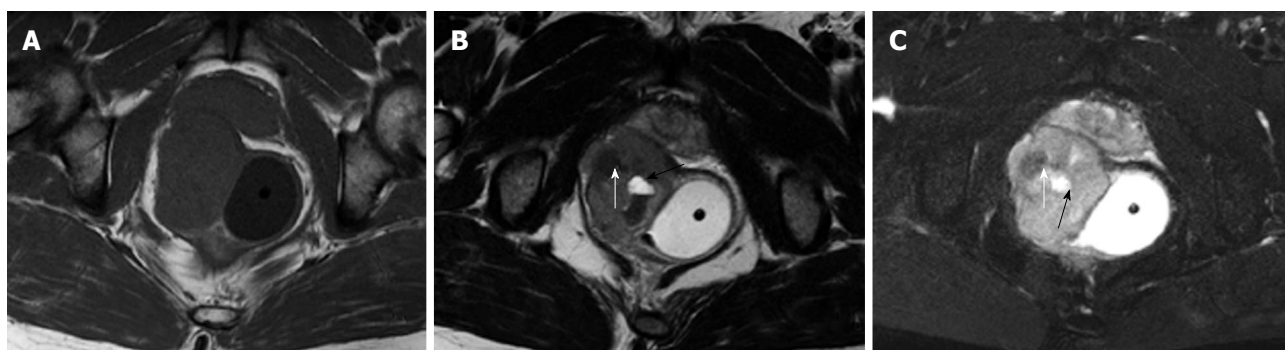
Gastrointestinal stromal tumors of rectum in a 44-year-old man. A well-circumscribed, smooth, intramural mass with exophytic growth expanded from the rectal wall and extended to the right ischiorectal fossa. The tumor displays low signal intensity on T1-weighted image (A), and high signal intensity on T2-weighted image (B, C). There are some areas of necrosis (black arrows) and fibrotic tissues (white arrows) in the tumor.
